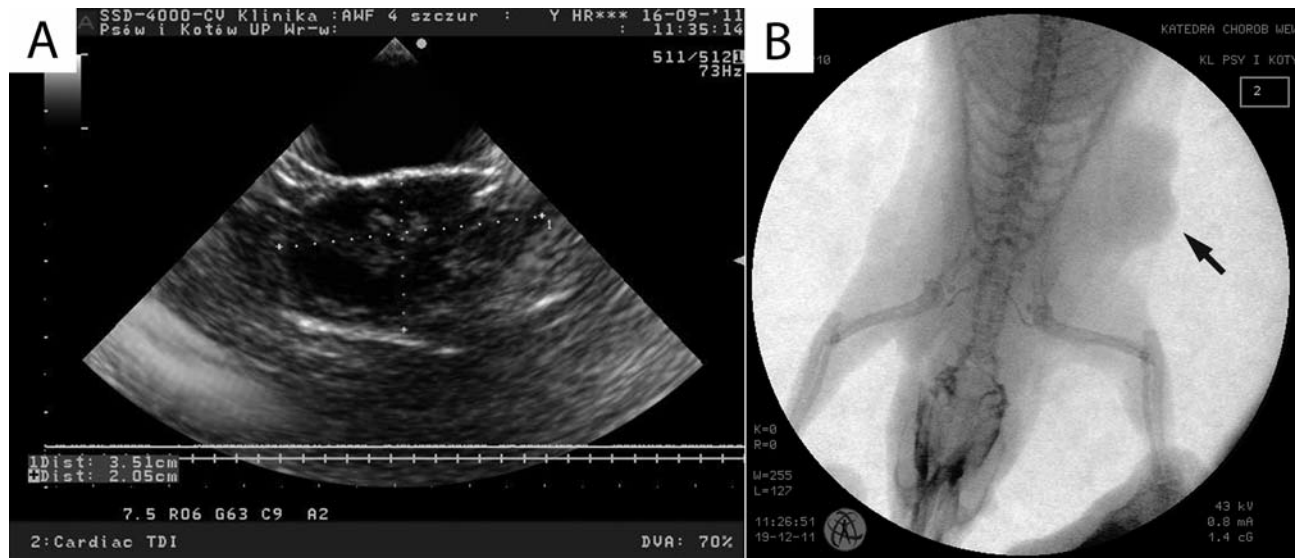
Tumours upon examination using ultrasonography appeared as hypodense, non-homogenic areas with signal enhancement noted in the tumour periphery (A). Radiographic examination of the thoracic area presenting a tumour mass (arrow) localized laterally in the projection area of the mammary ridge (B).
